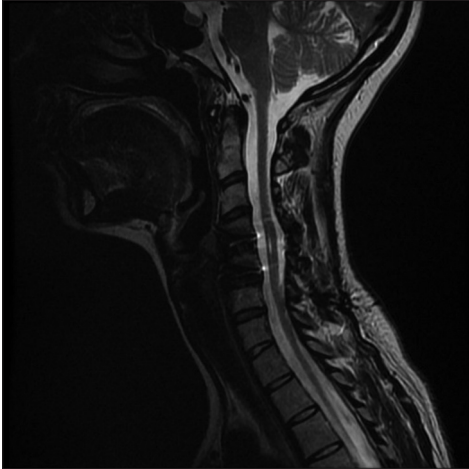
T2 Sagittal MRI confirming C4-C5 anterior/superior disc extrusion and a hyperintense signal within the spinal cord.
